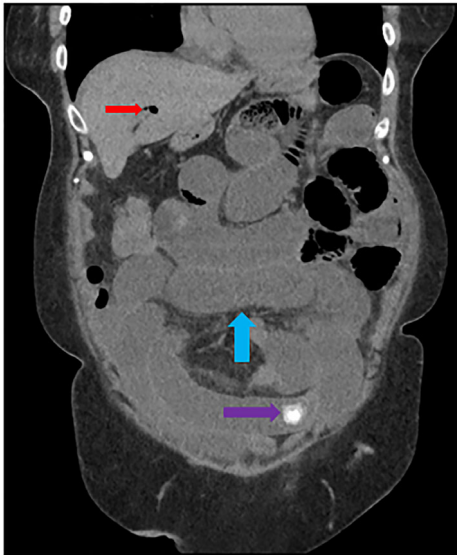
Abdominal and pelvic computed tomography showing bowel obstruction with a transition point at a 17-millimeter gallstone. Pneumobilia is also seen
